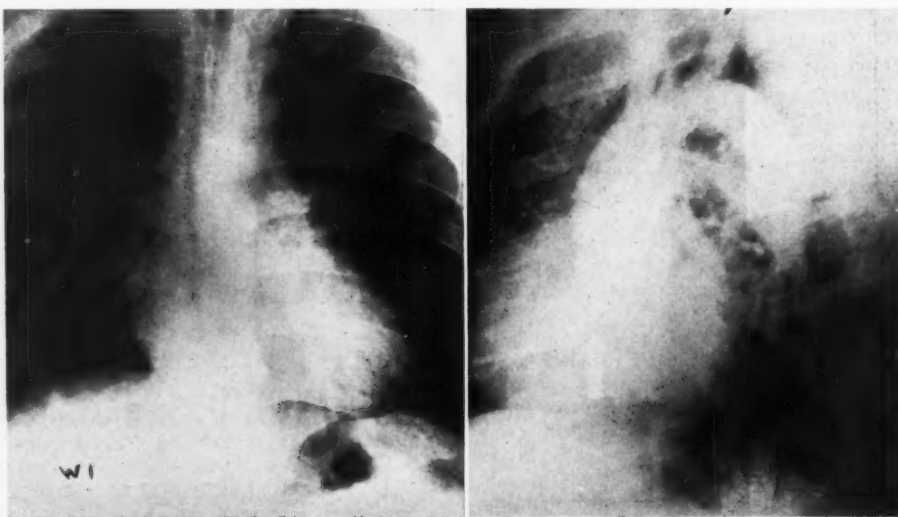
(*a* and *b*). Postero-anterior chest roentgenogram of a 29-year-old man who was wounded in the right anterior chest by a rifle bullet. Its exact location was undetermined until venous angiogram, performed in the severe left oblique projection by Dr. George P. Robb, demonstrated it to be embedded in the interventricular septum. Surgical removal was not indicated.
